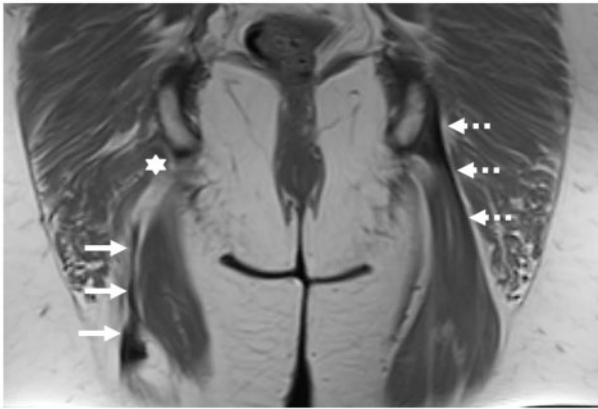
Coronal MRI with T2 sequence showing complete avulsion of the right proximal hamstrings with retraction and associated edema (three full white arrow), the 6-points star marks the normal attachment site at the IT. The contralateral normal attachment and course of the hamstring is outlined with three dashed white arrow
